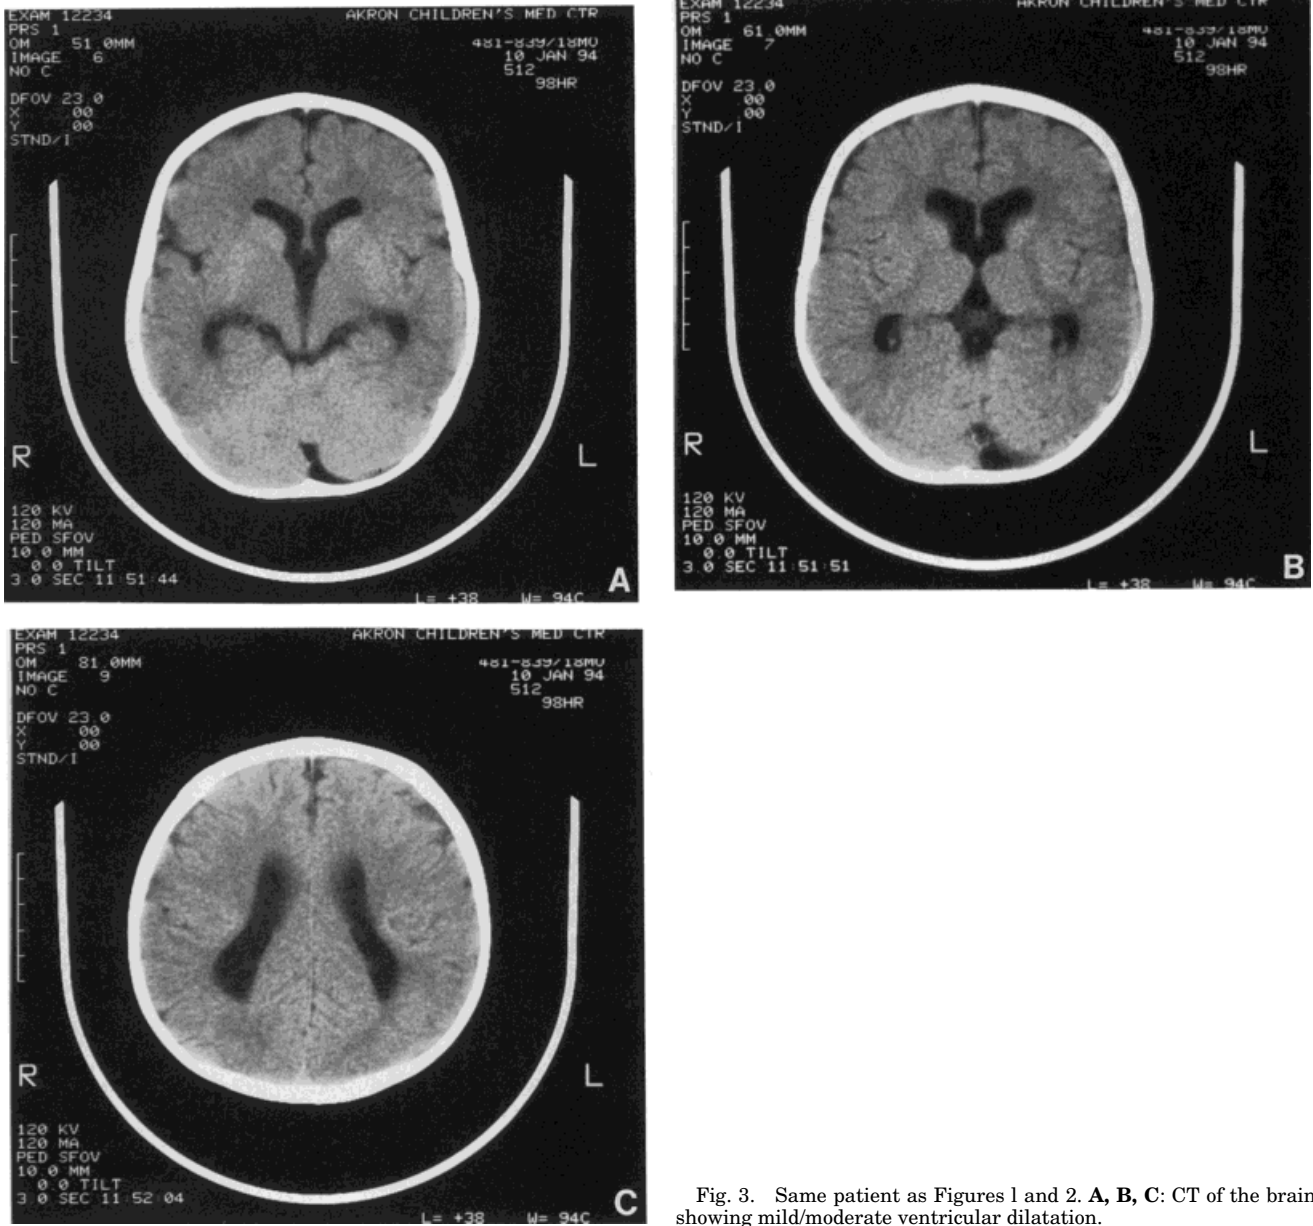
Same patient as Figures 1 and 2. A, B, C: CT of the brain showing mild/moderate ventricular dilatation.
